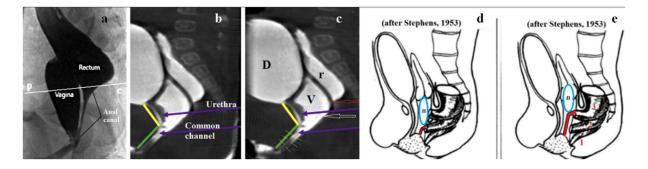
(a) ARM with anal ectopy in the lower part of the vagina. Contrast medium, introduced through a colostomy without the use of high pressure, revealed the vagina of normal width. At the time of the radiograph, the anal canal had time to contract. (b) MRI study from the article by Wood et al. [20], with the caption "Short common channel cloaca with adequate urethra." The authors suggest that, in the angle between the yellow and green lines, the urethra merges with the vagina to form a common channel. (c). In the copy of the same image (b), I
